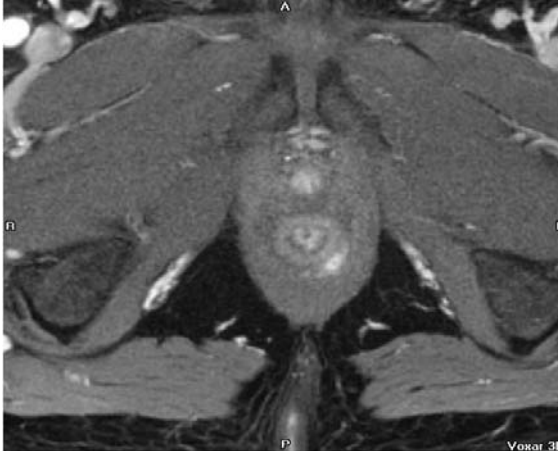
Axial T1-weighted image with fat saturation. Grade 1 intersphincteric fistula
